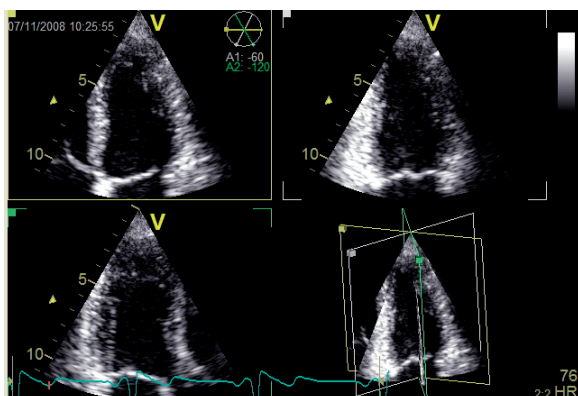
Real-time tri-plane echocardiography: 4 – 2 - and 3 chamber views are simultaneously displayed with 4-chamber as the reference view (*top left*). Interplane angles are set at 60 degrees but can easily be steered to any desired angle on their 3D representation (*bottom right*).
